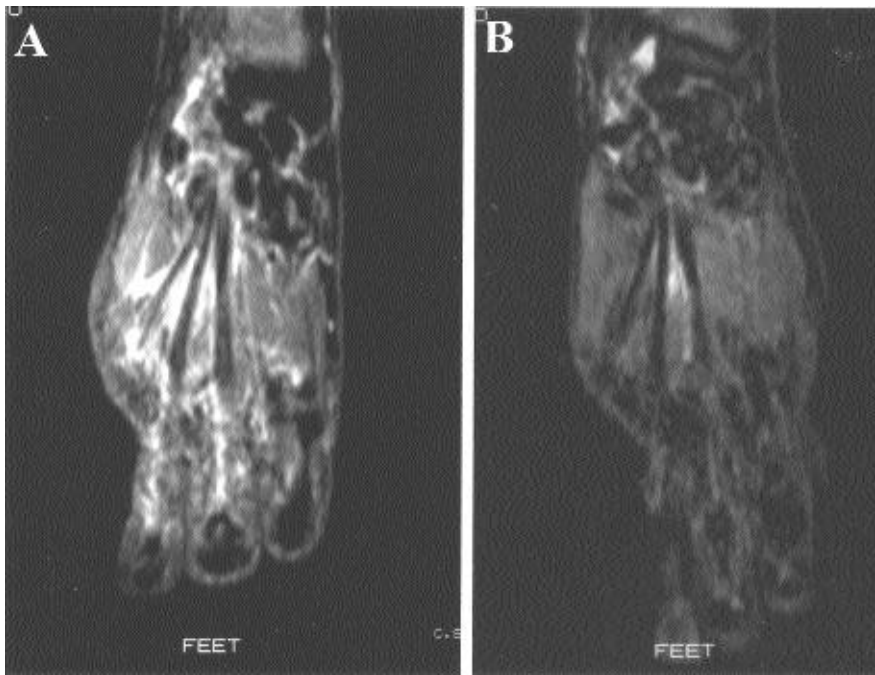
MRI (STIR sequences) of the hand in patient 3 before (a) and after treatment (b).
